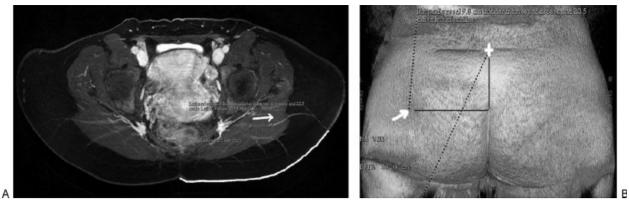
(A) Magnetic resonance imaging angiography (MRA; axial view). Arrow points to relatively large gluteal artery perforator. Curved red line demonstrates location of perforator calculated by measuring along curved skin surface from a point perpendicular to the point that perforator exits muscle fascia to the marker. (B) MRA three-dimensional reconstructed image demonstrating the location of the same perforator in relation to the marker along an x-, y-axis. The cross represents marker at superior point of gluteal crease. Arrow represents location of perforator at the skin surface.
